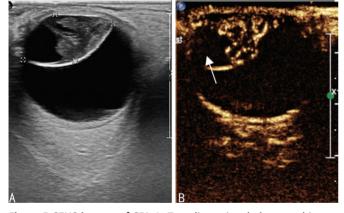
CEUS images of CBL A: Two-dimensional ultrasound image shows a hemispherical tumor with heterogeneous internal echogenicity, irregular cystic anechoic area, and hyperechogenic margin, displaying a "ring-shaped" margin; B: Contrast-enhanced ultrasound reveals the perfusion defect within the tumor corresponds to cystic anechoic area on two-dimensional ultrasound (arrows). CEUS: Contrast-enhanced ultrasound; CBL: Ciliary body mesectodermal leiomyomas.
